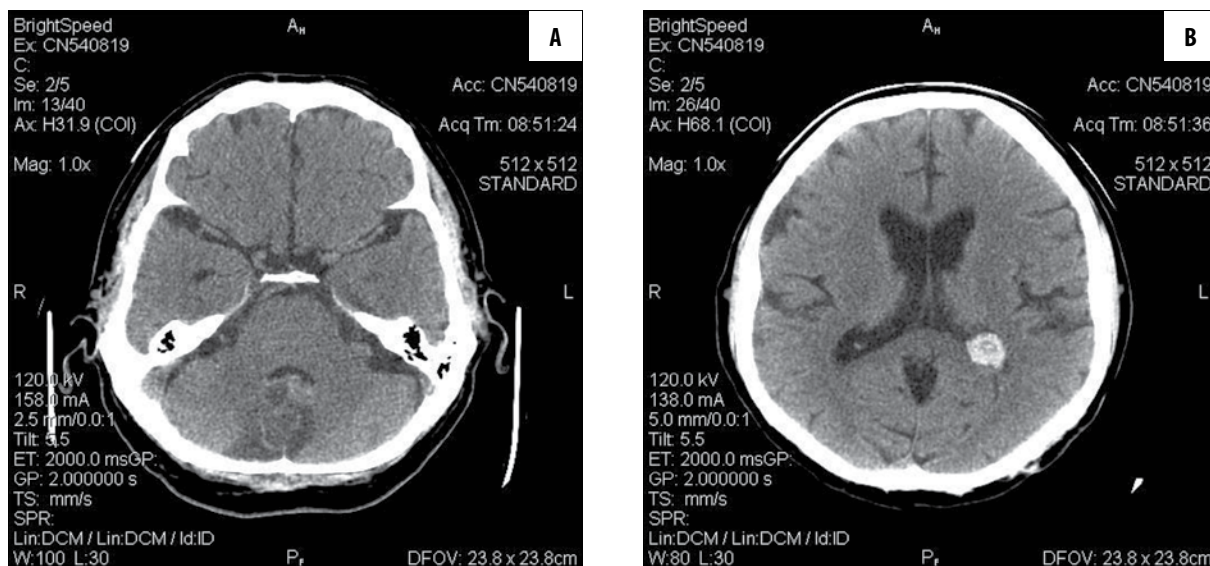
(A, B) Head CT without contrast.
